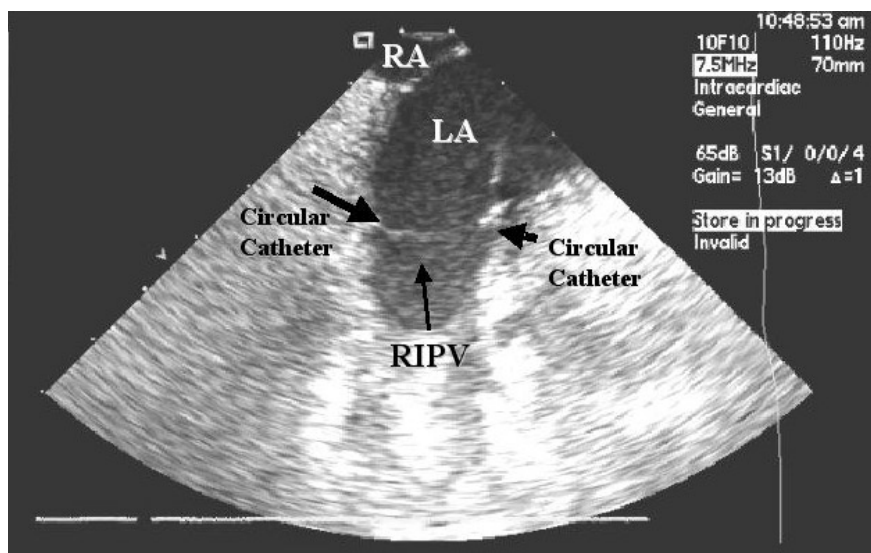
Example of the use of intracardiac echocardiography (ICE) to guide ostial positioning of a circular mapping catheter in the right inferior PV (RIPV). The circular catheter is placed on the atrial side of the PV-LA junction, allowing real-time monitoring and avoiding the need for PV angiography. LA Left atrium, RA right atrium
